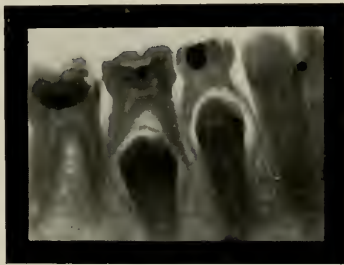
This picture shows that the temporary first molar should be extracted. The temporary second molar should not be extracted for a year or so, when the second bicuspid will be just ready to take its place. (Radiograph by Lewis, of Chicago.)
